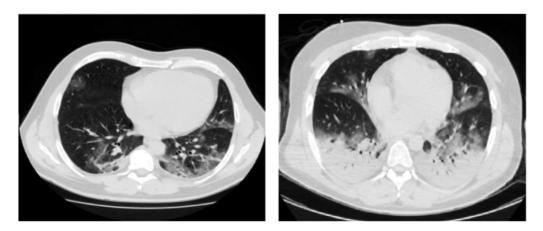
CT scans of the lungs of two patients with COVID-19 pneumonia that meet the requirements for ARDS Berlin definition. They recorded the following variable; Left: lung weight of 1192 gram, gas volume of 2774 milliliter, 8.4 percent of non-aerated tissue and pulmonary compliance of $80ml/cmH_2O$. Right: lung weight of 1441 gram, gas volume of 1640 milliliter, 39 percent of non-aerated tissue and pulmonary compliance of $43ml/cmH_2O$ (Gattinoni, Chiumello, et al., 2020).
